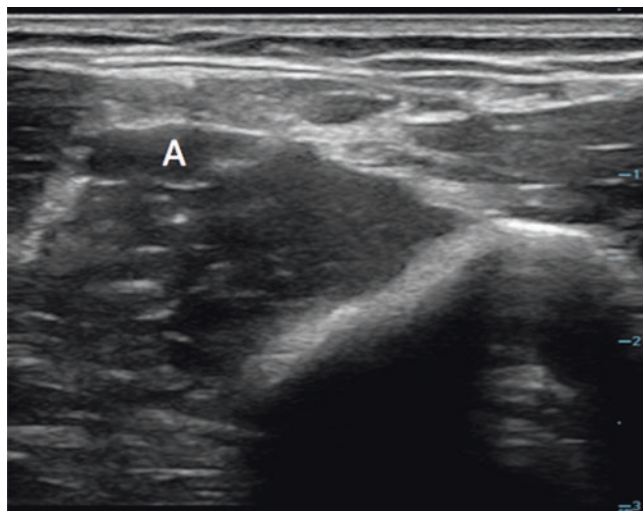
Ultrasound image of the medial upper arm veins under compression. The thin-walled veins fully compress with application of pressure, whereas the thicker-walled brachial artery (A) remains patent. Image courtesy of Stephen Alerhand
